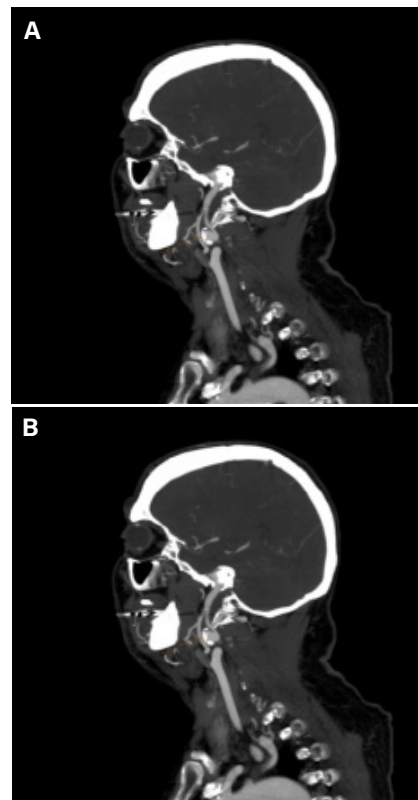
Sagittal CTA of the neck showing left ICA pseudoaneurysm (A) with dense atherosclerotic plaque and right ICA pseudoaneurysm (B) associated with large mural thrombus.
